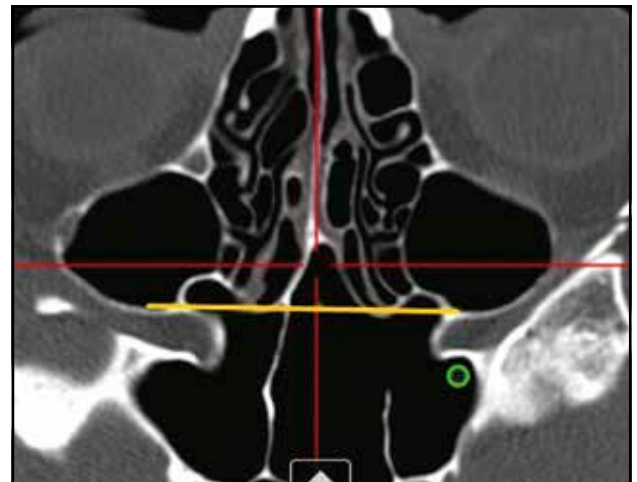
Sphenoidal recess extension (crano-facial CT scan, axial slice).
